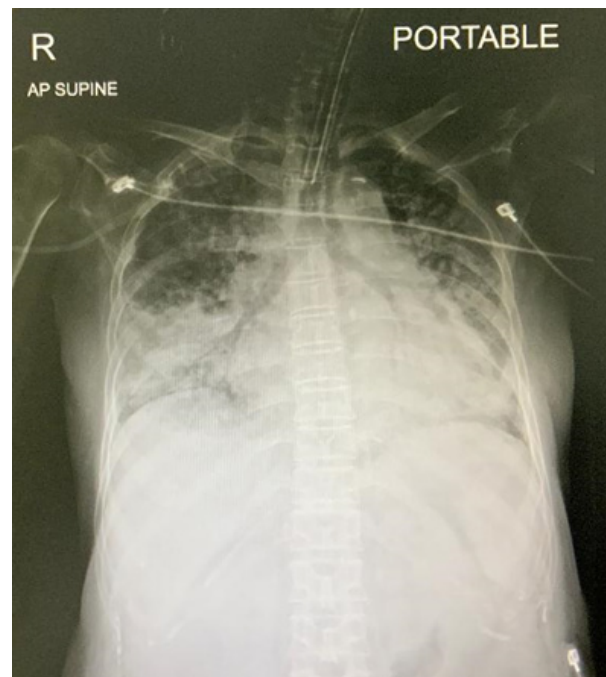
Chest X-Ray revealed bilateral, peripheral, lower lungs predominated consolidation.
